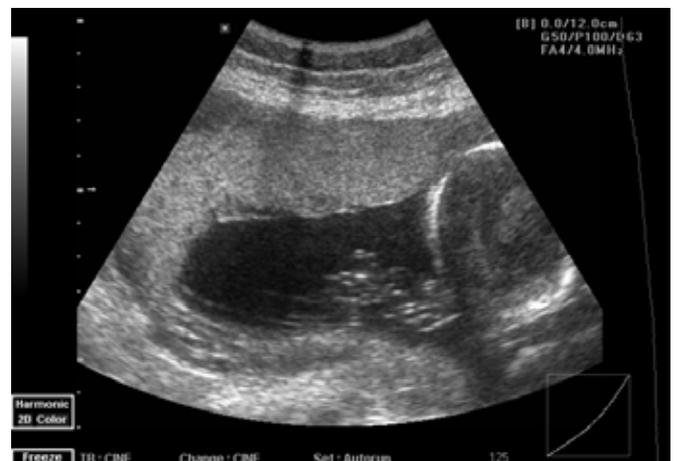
An anterior placenta of a 27 weeks pregnancy showing multiple placental cysts surrounded by calcification. Doppler study of umbilical vessels showed compromised uteroplacental circulation.
